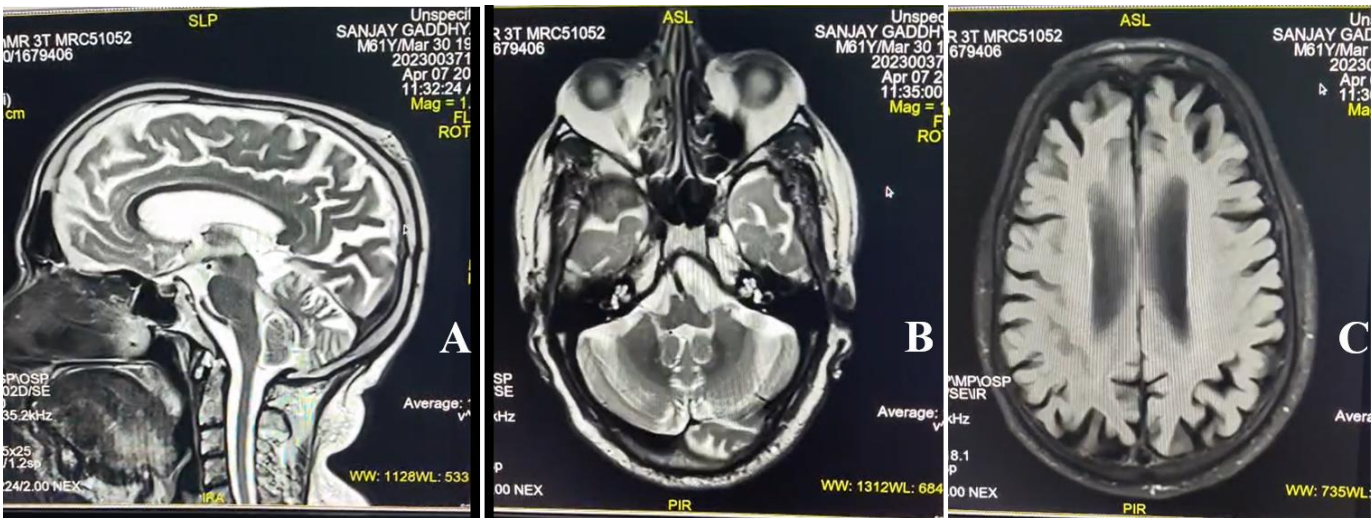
MRI image showing Vermian atrophy (A), bilateral superior cerebellar peduncle hyperintensity (B), and mild brainstem atrophy (C).
